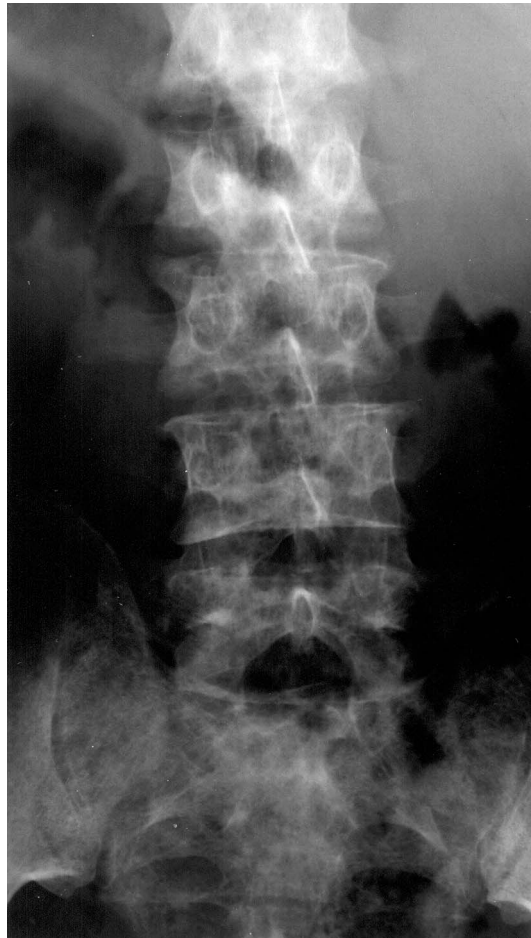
Plain radiographs showing a mixture of osteosclerotic and osteolytic lesions in the spine without the winking owl sign.
